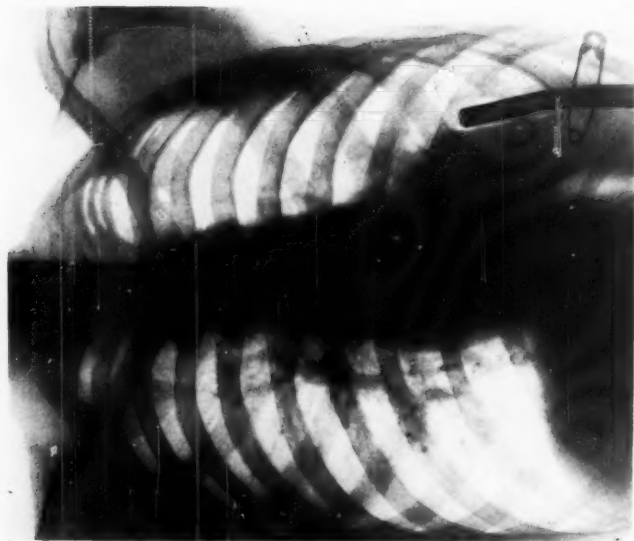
In this X-ray it seems as though the empyema on the left side has resolved and the tube is only draining the small pocket at its tip. (The exposure on the two halves of the film is different.) If this were so, the time to remove the tube has come, but the point cannot be verified without a pleurogram. The tube shown in this X-ray is barium-loaded.
